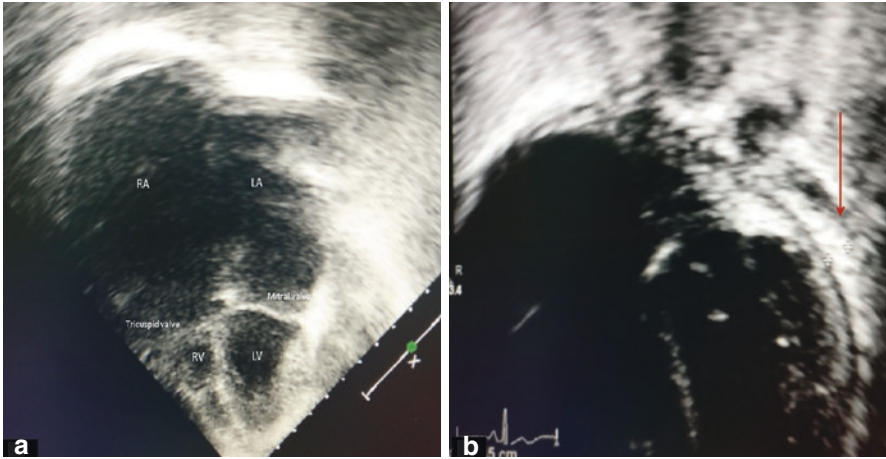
(a) Echocardiogram (apical four-chamber view) showing dilated right and left atria. (b) Echocardiogram showing thickened and calcified (arrow) pericardium
